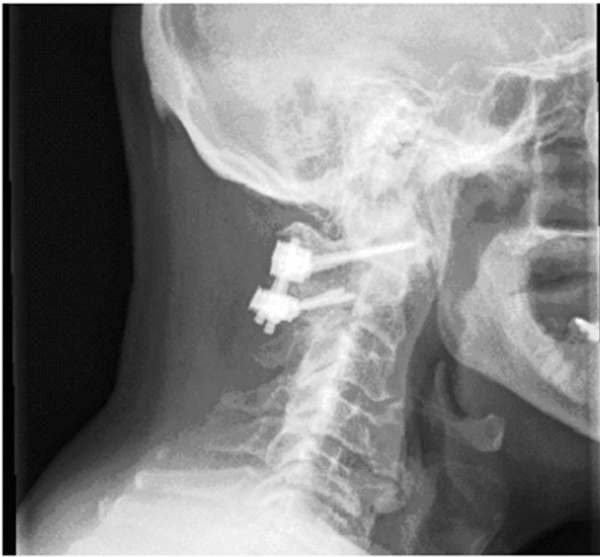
Lateral radiograph of cervical spine showing the polyaxial screw and rod construct used for arthrodesis of the lateral atlanto-axial joint.
